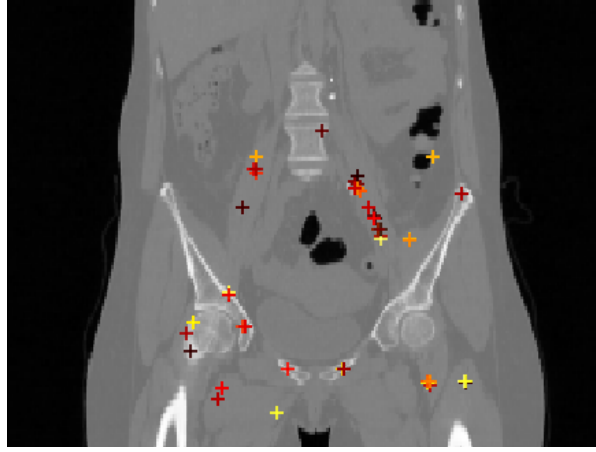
An example of generated landmarks on a CT scan, as seen from the coronal (front) view.
